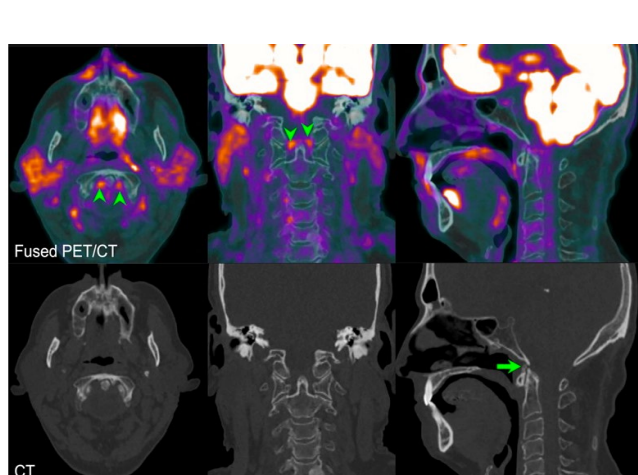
Fused ¹⁸F-FDG PET/CT sections (top row) and their corresponding low-dose CT (bottom row) extracted from TB-PET/CT for a 62-year-old man with PsA in axial (left), coronal (middle) and sagittal (right) views. Images demonstrate intense FDG uptake with rSUVmax 1.7 at the alar ligaments (arrowheads)
